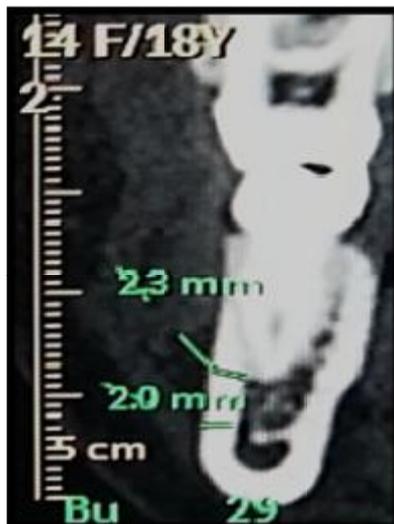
Dental Analysis of CT Image Showing Thickness of the Buccal Cortical Plate in Molar Area.
